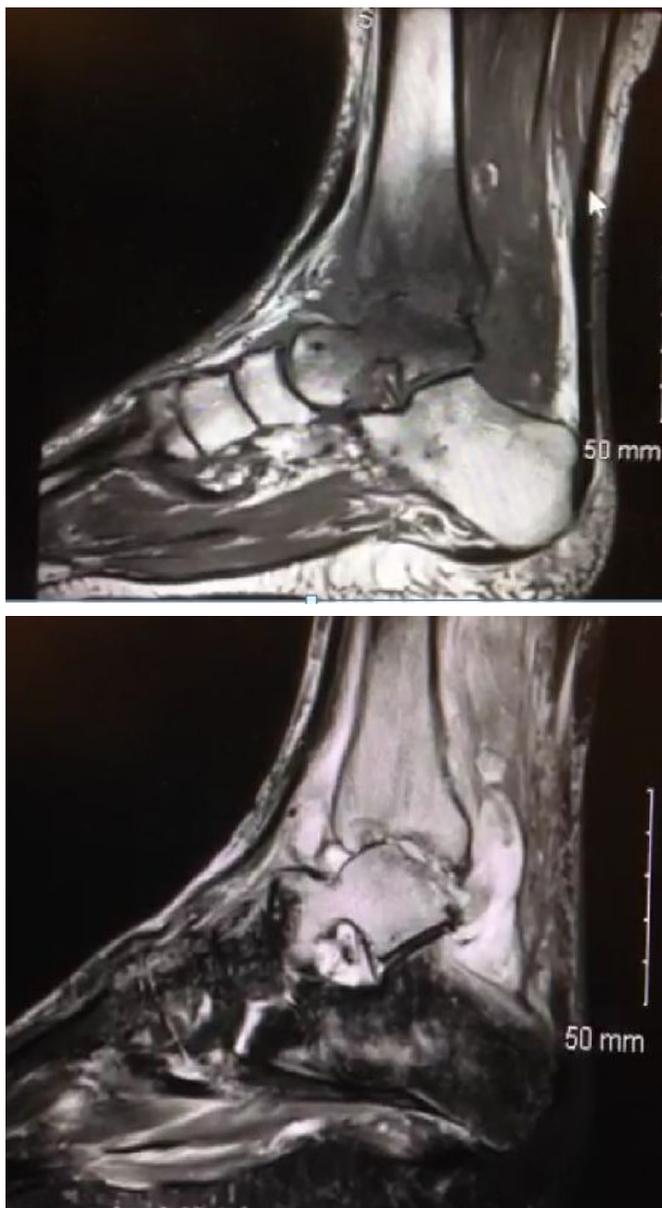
Pre-operative MRI; T1 Sagittal view, T2 Sagittal view.
